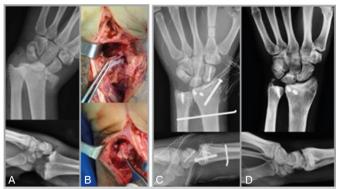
A) Unclassified radiocarpal dislocation, B) severe anterior capsular rent with associated FCT lesion, C) Immediate post reduction, D) Final radiographs.
